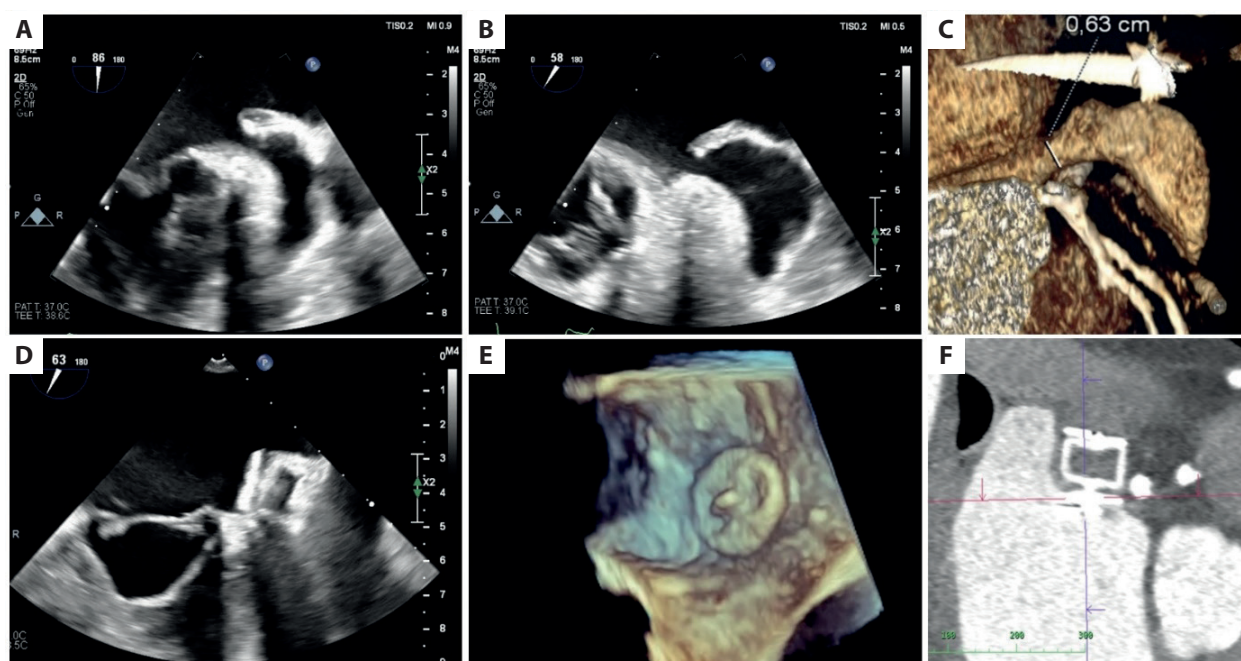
Pre- and post-procedural imaging. A, B. Transesophageal echocardiography (TEE) of left atrial appendage (LAA) before occlusion, showing atypical anatomy of LAA. C. Computed tomography (CT) three-dimensional reconstruction of LAA with thin neck. D. Two-dimensional TEE at 3-month follow-up showing AVP II occluder (Amplatzer Vascular Plug II, Abbott, Plymouth, MN, US) successfully closing LAA. E. Three-dimensional TEE at 3-month follow-up showing ostium of LAA completely covered by proximal occluder disc. F. CT at 3-month follow-up showing no contrast leak behind proximal occluder disc, confirming complete LAA occlusion
